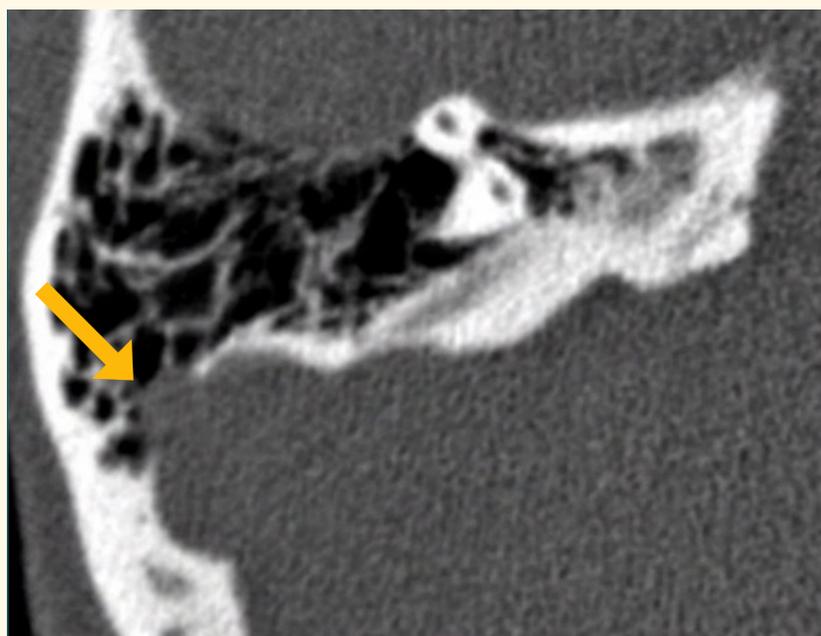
Axial CT showing right sigmoid sinus diverticulum (arrow).
